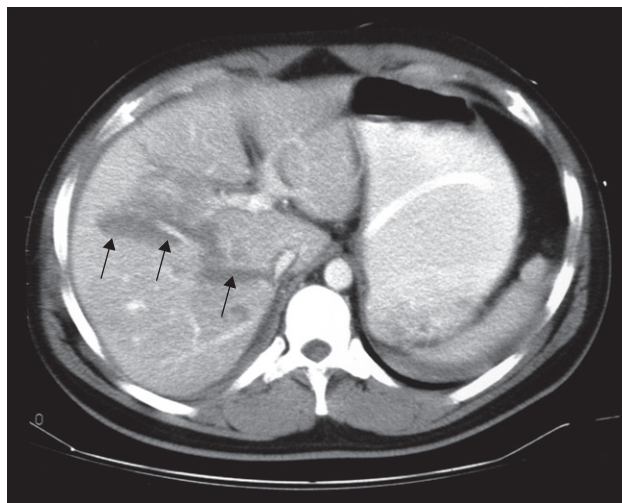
Liver trauma. CT scan showing laceration in the right lobe of the liver (arrows). A nasogastric tube is present in the stomach.
